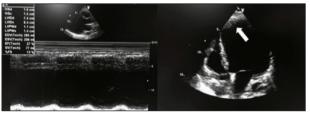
Echocardiographic findings after 6-month ICD-CRT implantation. Please note that both heart dimensions and ejection fraction are unchanged. A blood clot (thrombus) in the left apical ventricle can be observed (white arrow).
